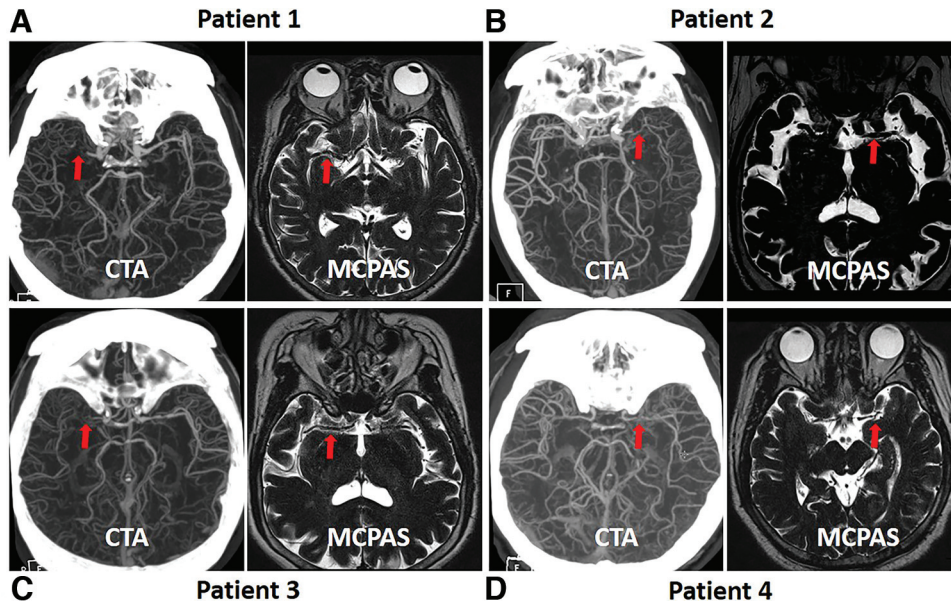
The image data of patients 1–4. A–D, The CTA and MAPAS images of 4 patients with MCA occlusion (including 2 right MCA occlusions and 2 left MCA occlusions). The red arrows indicate the vessels with lesions.
